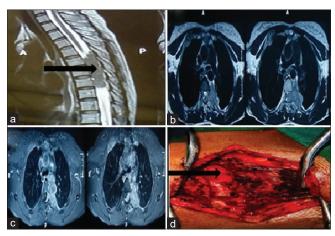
(a) Magnetic resonance imaging thoracic spine s/o T2 sagittal image showing well-defined lesion hypointense, extradural in location compressing thecal sac. (b) T2 axial images showing well-defined extradural lesion hypointense, compressing thecal sac on right side and involving bone and muscle. (c) T1 axial contrast images s/o heterogeneously enhancing extradural lesion on right side compressing thecal sac involving bone and muscle and extending into thoracic cavity. (d) Intraoperative lesion encasing thecal sac with compression and extradural in location. Right > left. (Black arrow showing compressive lesion)
